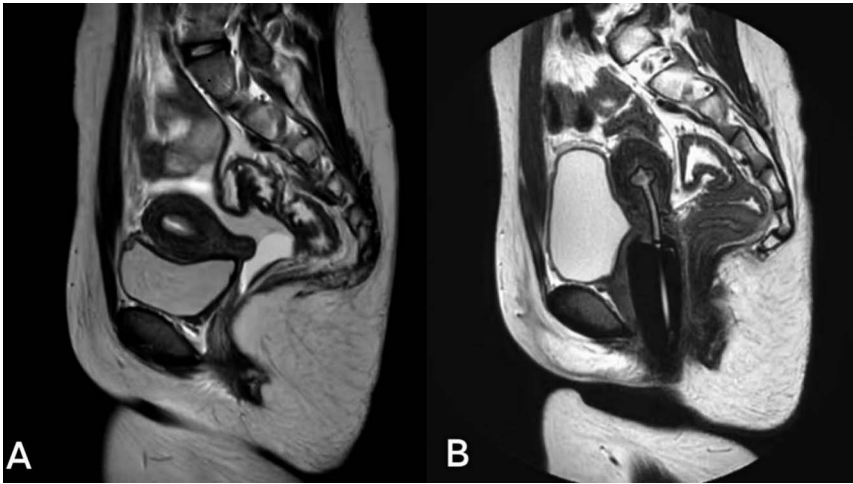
MRI of patients with type II vaginal atresia before and after the surgical procedure. (A) MRI of patient with type II vaginal atresia before the surgical procedure. (B) MRI of patient with type II vaginal atresia after the surgical procedure. MRI = magnetic resonance imaging.
